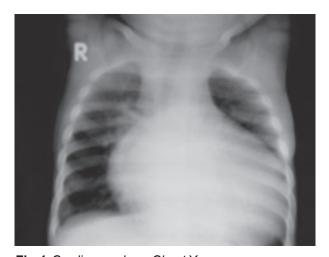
Cardiomegaly on Chest X-ray.
